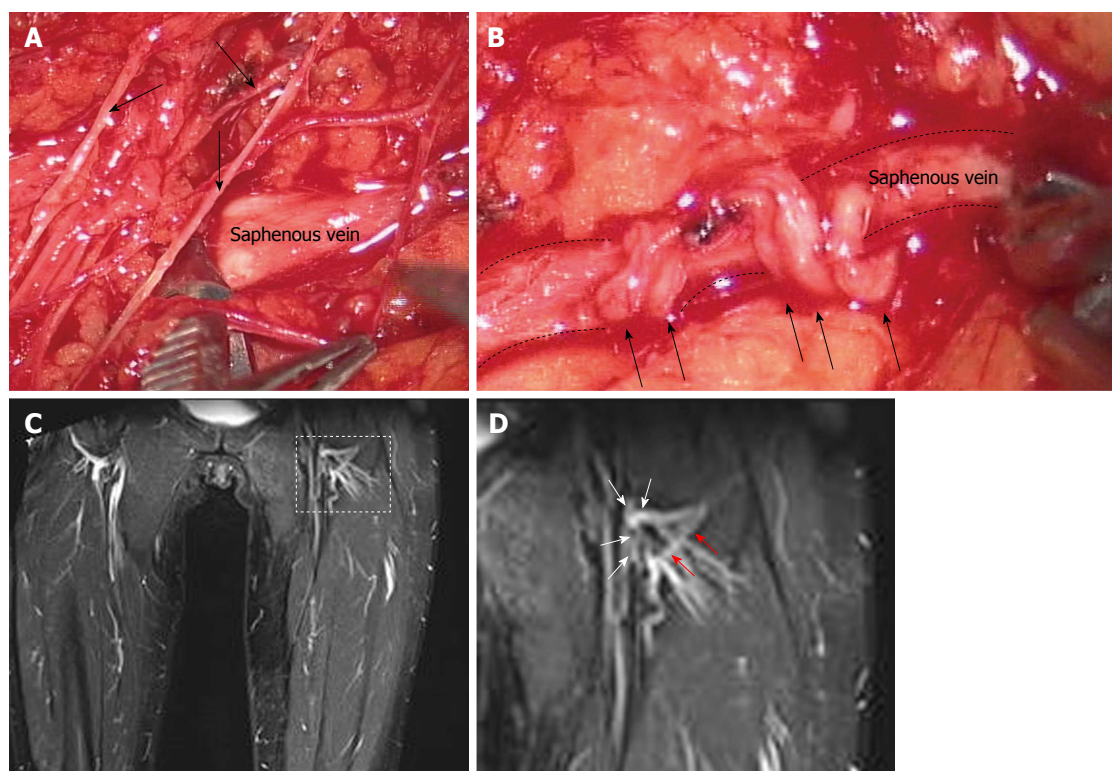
Lymphatic meshes were observed not only in patients who underwent spermatic funicular microsurgery, but also in patients who positively responded to the treatment of the lower limb swelling. A: Microsurgical identification of the saphenous vein and of lymphatic vessels (arrows) in the crural area; B: Latero-terminal lympho-venous anastomosis, confectioned with interrupted stitches, between lymphatic vessels (arrows) and the saphenous vein (dashed line) in proximity of the femoral-saphenous cross; C: Magnetic resonance image of the lower limb obtained in the same patient of A, B at 8 years after microsurgery. Details of the left limb crural area (delimited by the dashed line) are presented in D; D: White arrows identify the sites where latero-terminal lympho-venous anastomosis were confectioned, while red arrows focus on a new developed lymphatic collector.
